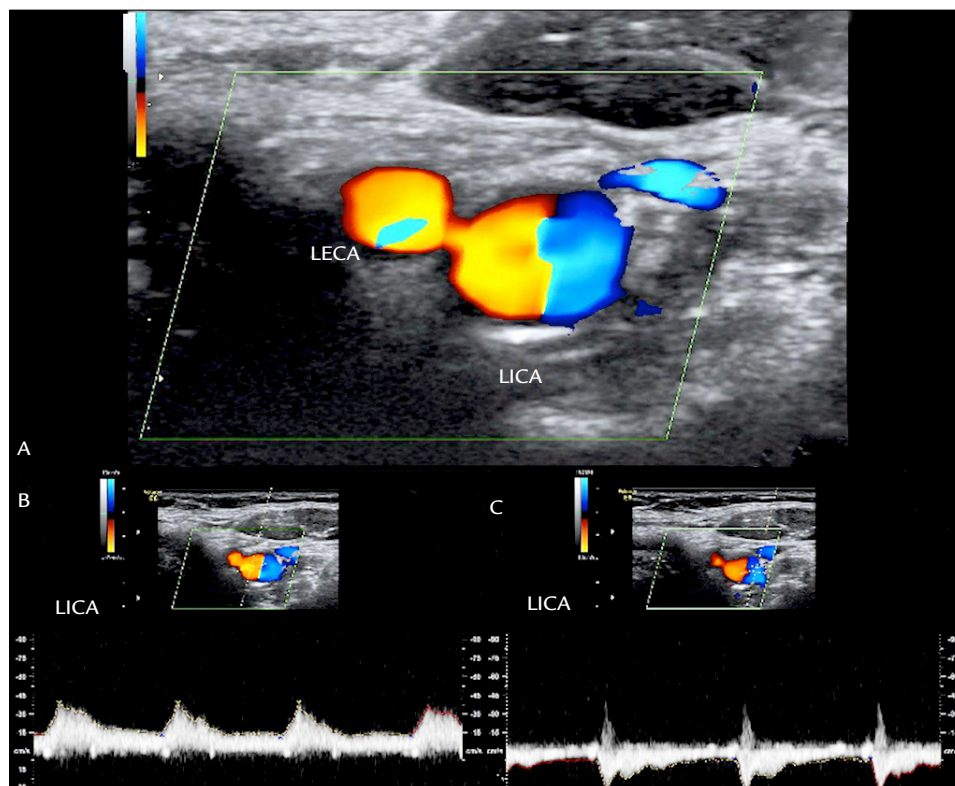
Doppler vascular ultrasound, six months after initial event. A. Color mode with *ying yang* image. B. Spectral mode, true lumen. C. Spectral mode, false lumen. LICA: left internal carotid artery; LECA: left external carotid artery.
